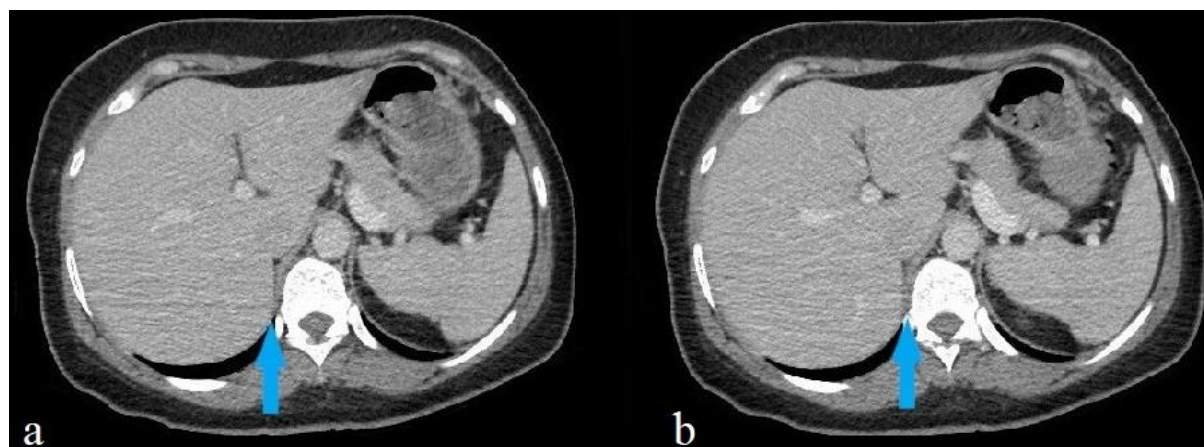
(a), (b): Follow-up contrast-enhanced computed tomography sections show resorption of the hematoma (blue arrow).
